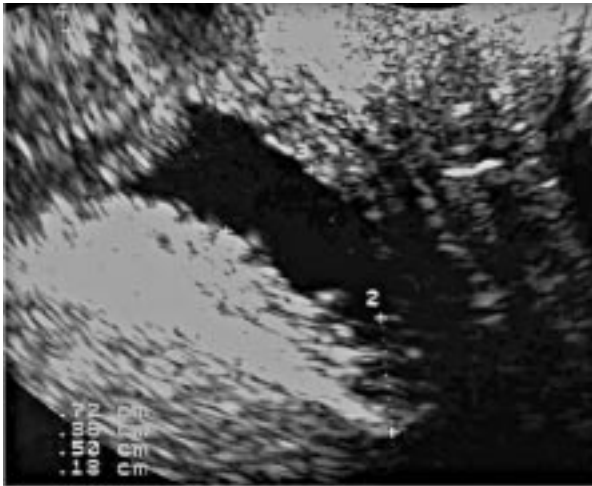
Sonographic bladder wall thickness
